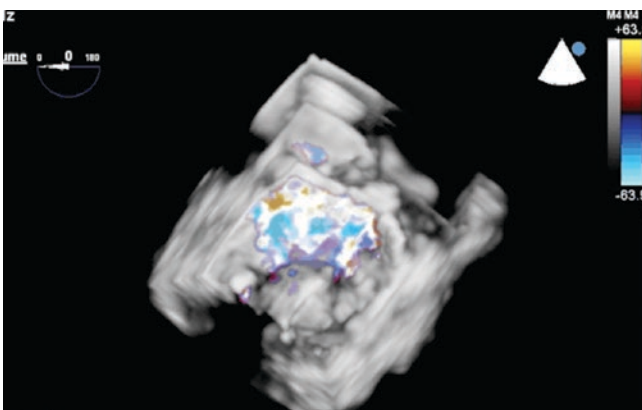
3D echocardiography with color can be used to identify the origin of mitral regurgitation. Shown is an example of P2 prolapse. When 3D with color is used, one can visualize the mitral regurgitation originating from the P2 scallop and directed anteriorly
